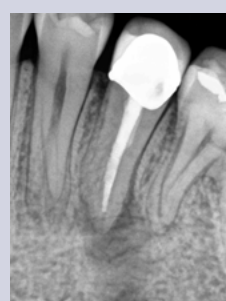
Periapical radiograph of tooth #20. There is an associated radiolucency at the apex of this root-filled tooth.
